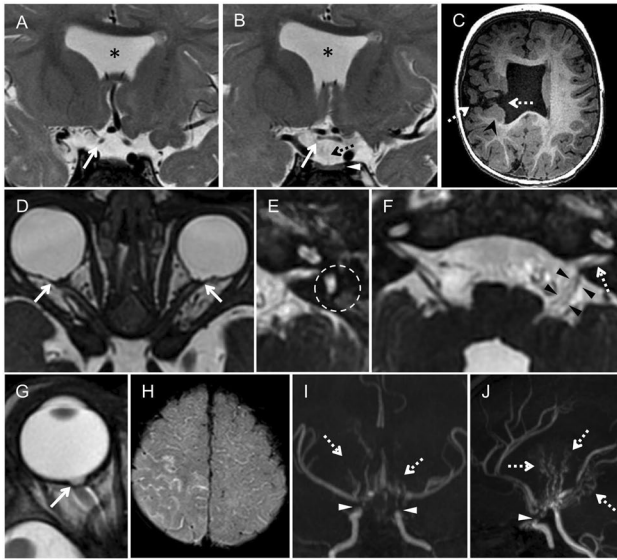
Different examples of congenital optic nerve anomalies. Coronal T2-WI (A and B) and axial T1-WI (C) show unilateral right-sided optic nerve hypoplasia (arrows in A and B) in a 10-months-old male infant. Additional findings include absence of the septum pellucidum (asterix in A and B), a small pituitary gland (arrowhead in B), with a barely visible hypoplastic pituitary stalk (dotted arrow in B), and unilateral schizencephaly (dotted arrows in C) with adjacent polymicrogyria (arrowhead in C). This may be referred to as septo-optic dysplasia plus. Axial 3D FIESTA reconstructions (D-F) show bilateral optic nerve colobomas (arrows in D) in a 5-months-old male infant, with associated bilateral semi-circular canal aplasia (left side shown; traced circle in E), left-sided facial-vestibulocochlear nerve complex hypoplasia (arrowheads in F) and slight stenosis of the internal auditory canal (dotted-arrow in F). This is a case of CHARGE syndrome. Axial T2-WI (G) showing a morning glory disc anomaly in a 6-months-old male infant. Axial T2-FLAIR (H) shows bilateral sulcal hyperintensities – ivy sign (most prominent on the right hemisphere). Coronal (I) and sagittal (J) MRA MIP reconstructions show marked stenosis of the terminal supraclinoid internal carotid arteries (arrowheads in I and J) and extensive lenticulostriate and thalamoperforating collaterals (dotted-arrows in I and J). This is Moyamoya disease.
